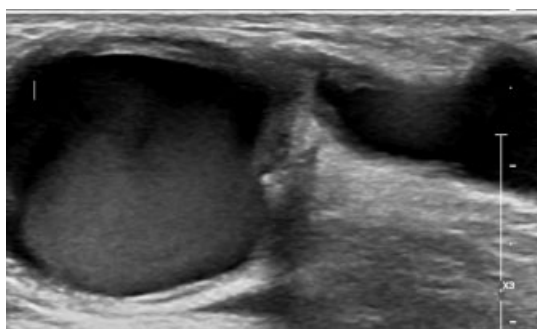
Ultrasound of arteriovenous fistula (AVF) showing a juxta anastomotic tight stenosis and aneurysmal dilatation.
